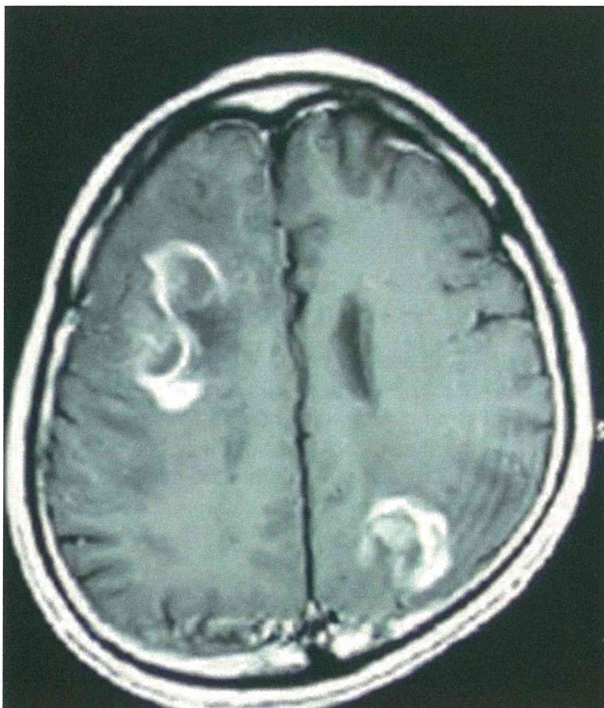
T_1 -weighted contrast-enhanced magnetic resonance imaging scan shows high-signal foci in the right frontal lobe and the left parietal lobe.
